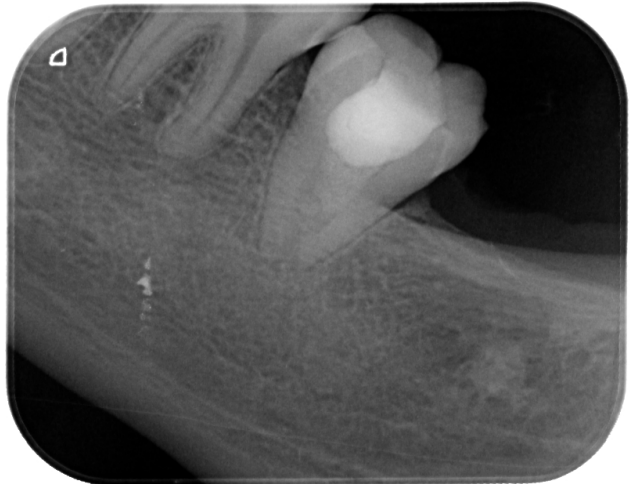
36-month follow-up radiograph
